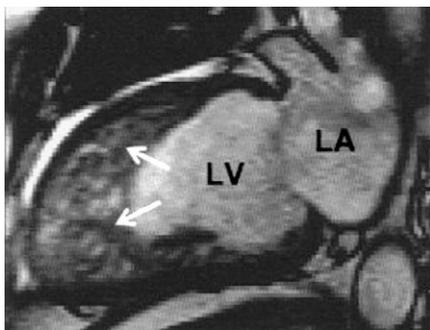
Cardiac magnetic resonance image of the LV showing prominent muscular trabeculations (white arrows) with deep intertrabecular recesses. Abbreviations: LA indicates left atrium. Reproduced with permission from the Oxford Press, *European Journal of Cardiology*, doi:10.1093/eurheart/ehm625.
